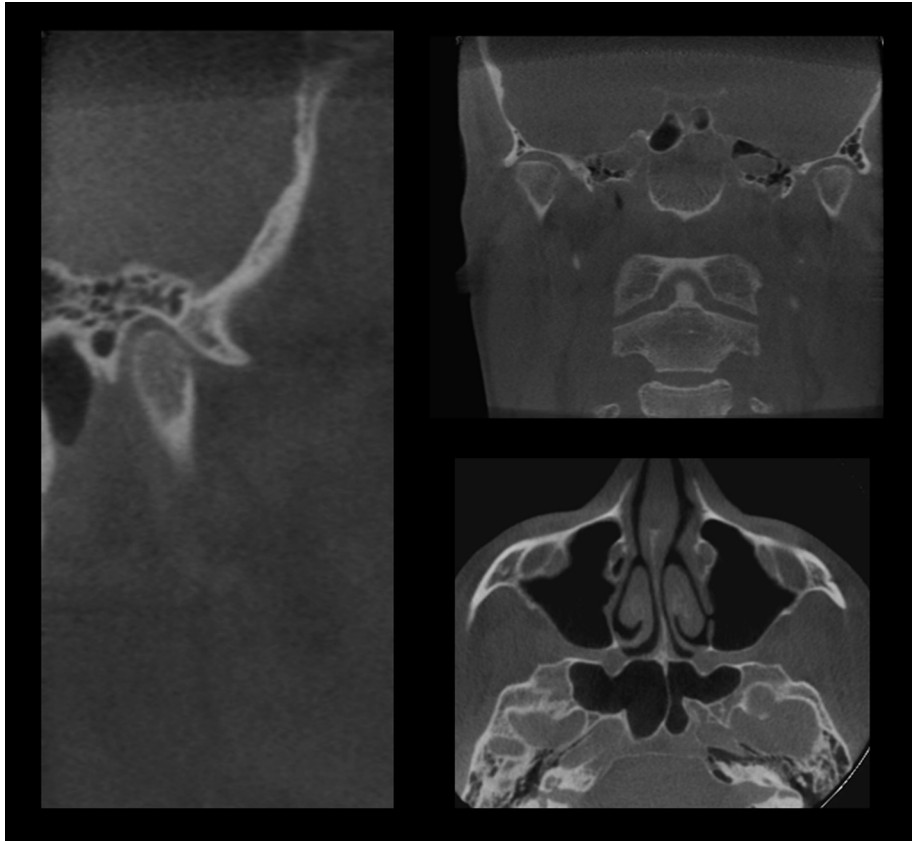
CBCT image (Multiplanar reconstruction) showing an example of multilocular bilateral pneumatized TMJ fossa.
